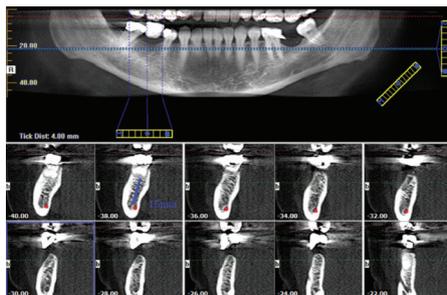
Patient CBCT showing 10 slices in the LR6 region
